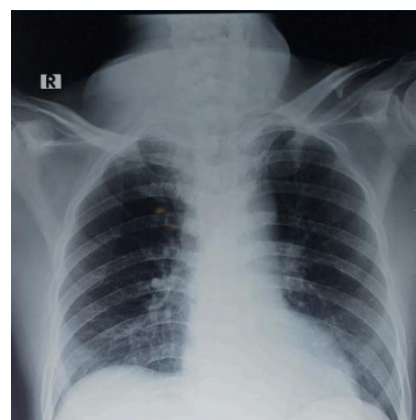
(Left) Clinical presentation of a patient showing a lump in his neck. No signs of inflammation were observed. (Right) Chest X-ray showing soft tissue mass in the right and left side of the neck (VC4-VT 2).
